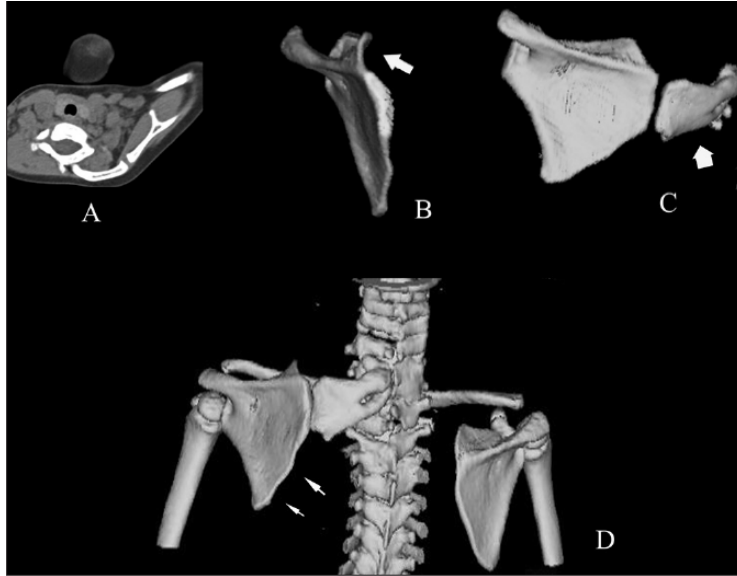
CT scan (A) and 3D reconstruction (B, C and D) show the omovertebral connection (thick arrow) arising from the medial border of the scapula and the vertebral column. (B) shows anterior curving of the suprascapular portion of the affected scapula (arrow). (D) shows the convex medial border and the concave lateral border of the affected scapula (multiple arrows) [52].
